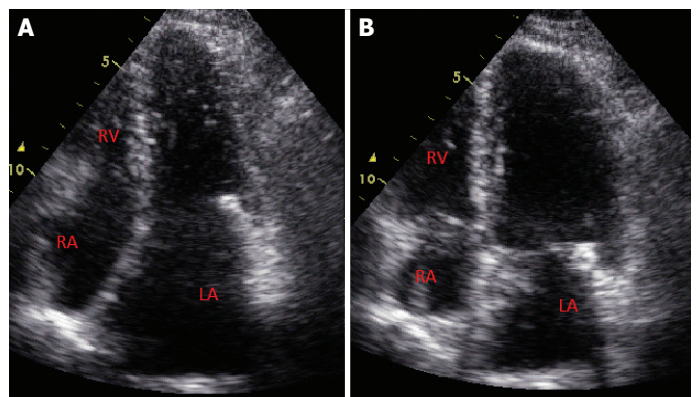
Control TTE showing full recovery in apical 4-chamber view after two weeks. (A) Left ventricle systole. (B) Left ventricle diastole.
